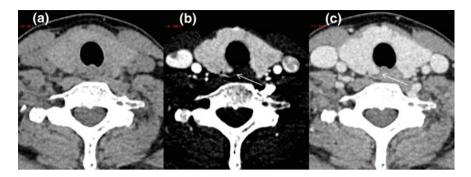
Parathyroid adenoma. a non-contrast CT. b Arterial phase CT. c Delayed phase CT. Notice the parathyroid adenoma (*arrow*) demonstrates early enhancement compared to the thyroid tissue background with early washout on the delayed image
